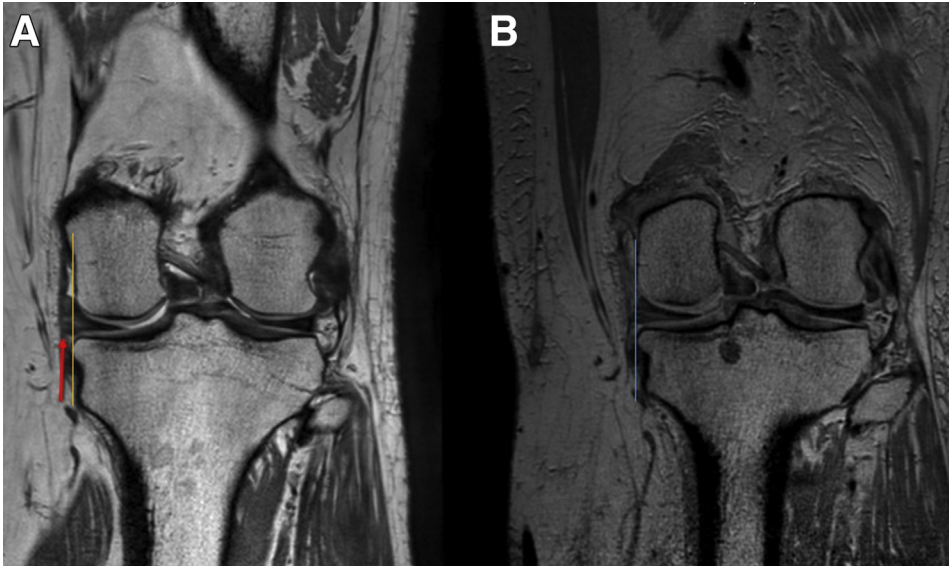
(A) Preoperative MRI of the right knee, coronal view. Significant meniscal extrusion can be seen on the posterior horn of the medial meniscus (arrow). (B) Postoperative MRI of the same patient. Appropriate reduction of the extruded meniscus was achieved. (MRI, magnetic resonance imaging.)
